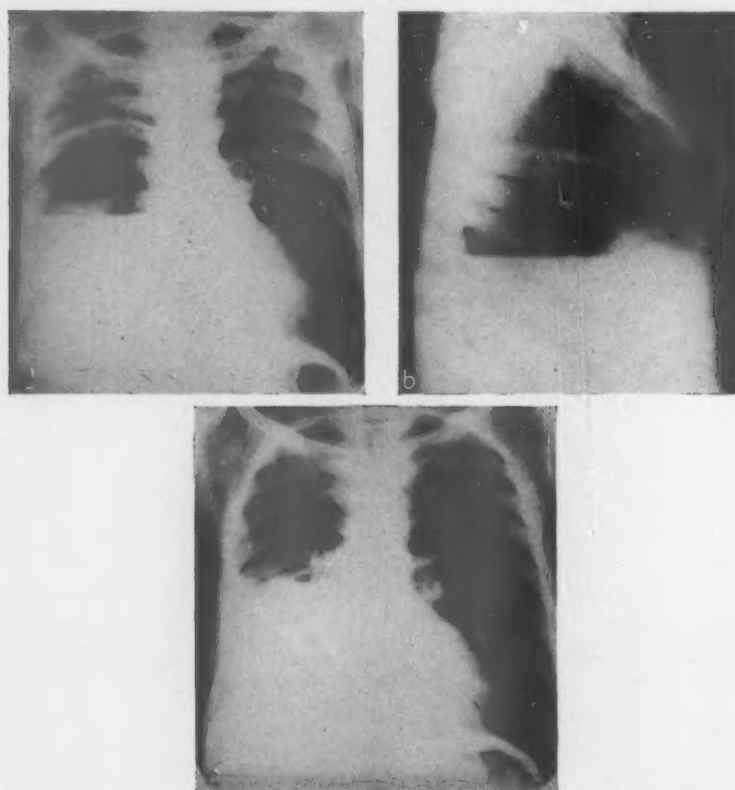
(a) Postero-anterior radiograph of a patient with spontaneous broncho-hepatic fistula. (b) Lateral radiograph of the same patient. (c) Seven weeks later, after specific therapy. At no stage was pus aspirated
